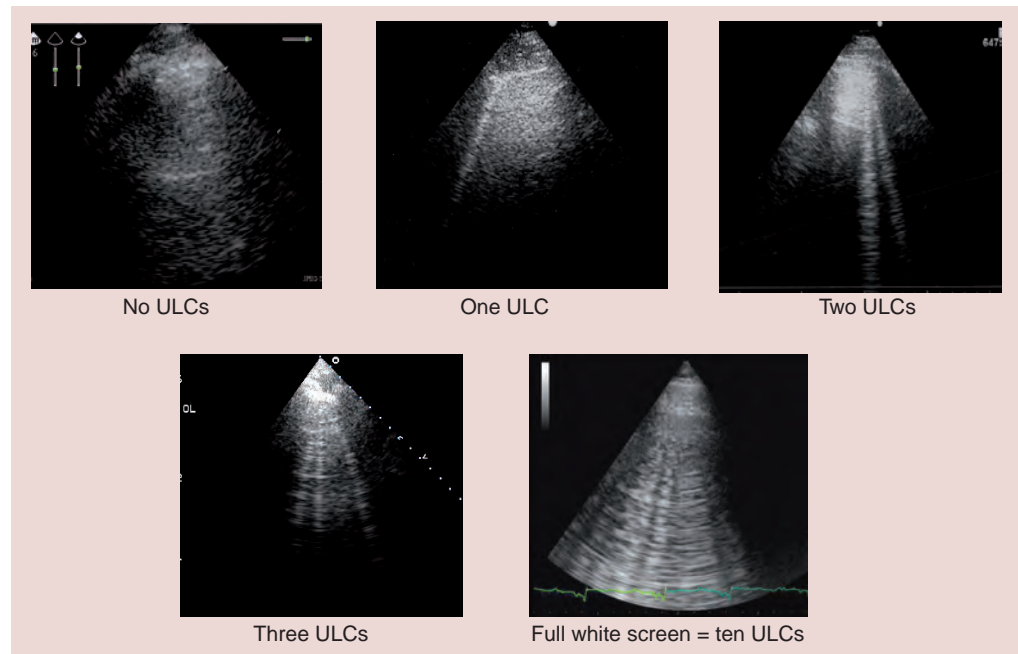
How to enumerate ultrasound lung comets: each hyperechoic vertical stripe, spreading from the pleural line and extending to the edge of the screen is an ultrasound lung comet. A whole white screen, making it almost impossible to distinguish and enumerate different ULCs, is considered as corresponding to a plateau value of ten ULCs. ULC: Ultrasound lung comet.
